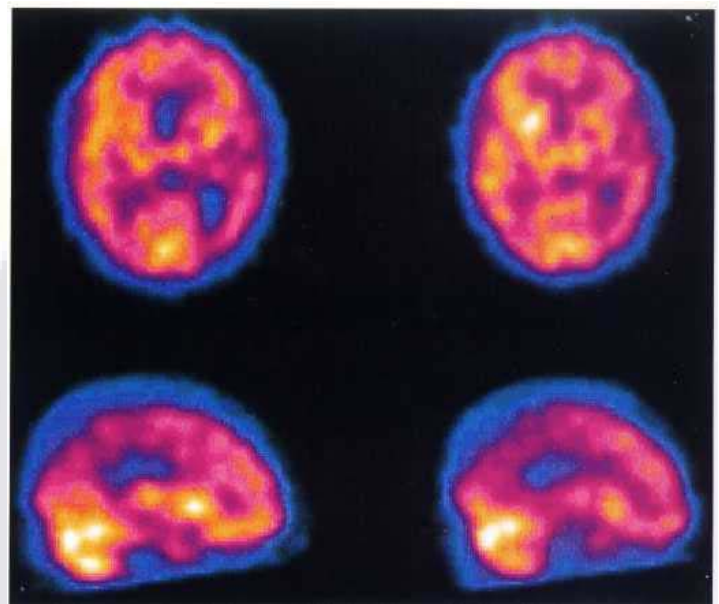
^{19m}Tc -exametazime brain SPECT: axial (top row) and left and right parasagittal (bottom row) sections in a patient with suspected Alzheimer's disease. The distribution is primarily posterior but quite asymmetric, unlike Fig. 58.96.
